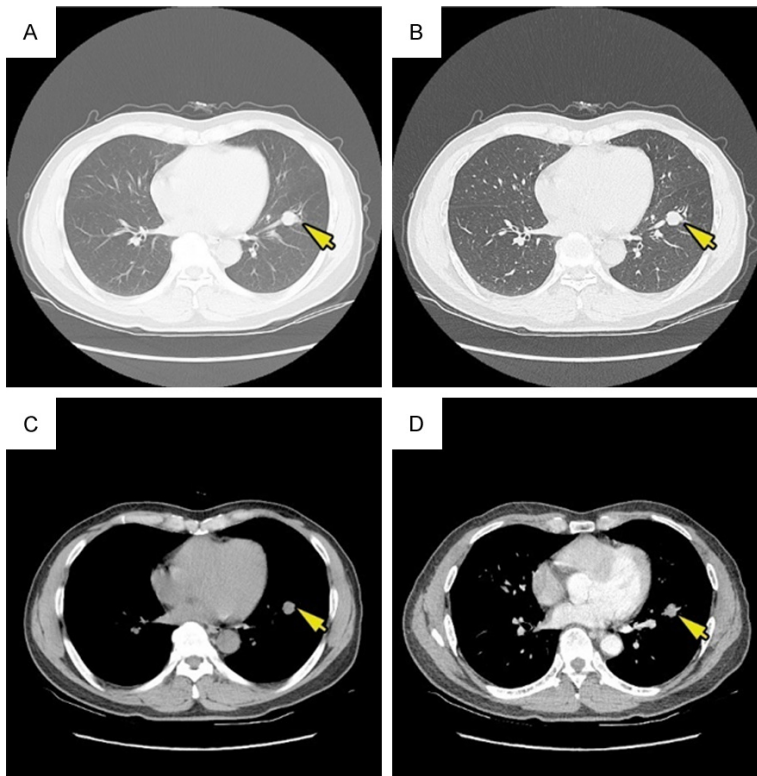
Imaging examination results of the patient. A-D: Contrast-enhanced CT revealed a nodule in the inferior lobe of left lung with the obstruction of basal segmental bronchus. The arrows indicate the mass.
